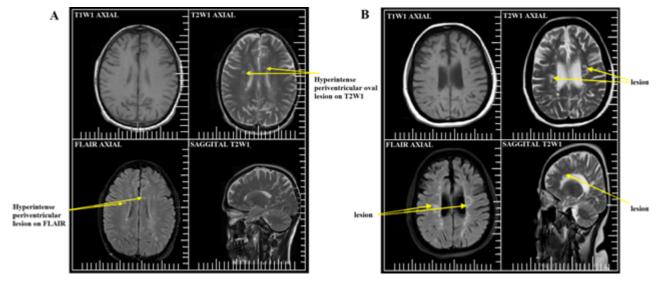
(A) A 29-year-old male patient: axial T1-weighted imaging (WI), T2WI, fluid-attenuated inversion recovery (FLAIR) imaging, and sagittal T2WI showing oval shaped white matter periventricular lesions; (B) a 38-year-old female patient: axial T1WI, T2WI, FLAIR, and sagittal T2WI showing oval shaped white matter periventricular lesions (Philips Achieva 1.5 T Nova Dual system)
